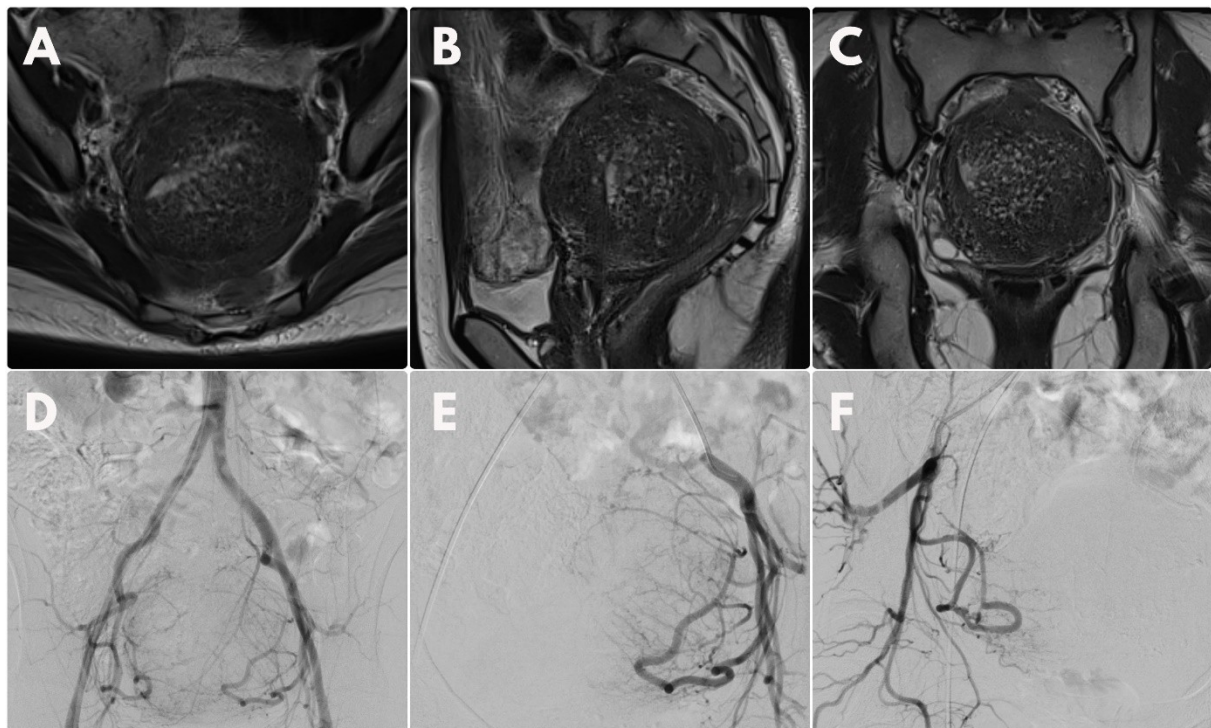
A–C. 45-year-old patient with adenomyosis confirmed by MRI; D. Initial angiography confirmed the presence of enlarged uterine arteries. Bilateral selective angiography of uterine arteries before embolization
